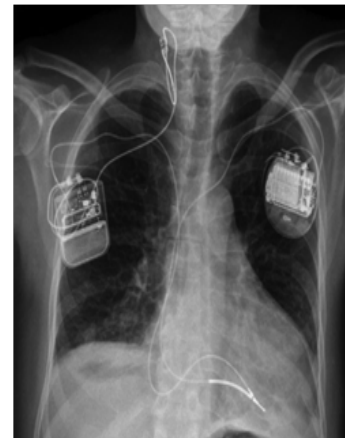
Radiograph of an implanted CardioFit System, showing the CardioFit implant on the patient's right and a previously implanted defibrillator on the left. Two leads are in the RV apex: one is the sensing lead from the CardioFit device (28).
